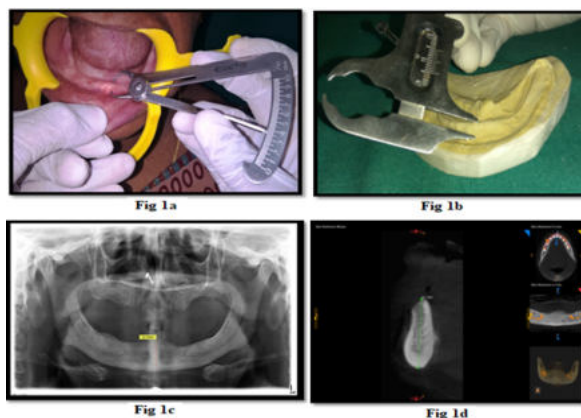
Presurgical Assessments- (1a) Clinical depth vestibular depth measurement (1b) vestibular depth measurement as on study model (1c) Radiographic vertical depth measurement as on OPG and (1d) CBCT (Carestream Software).
